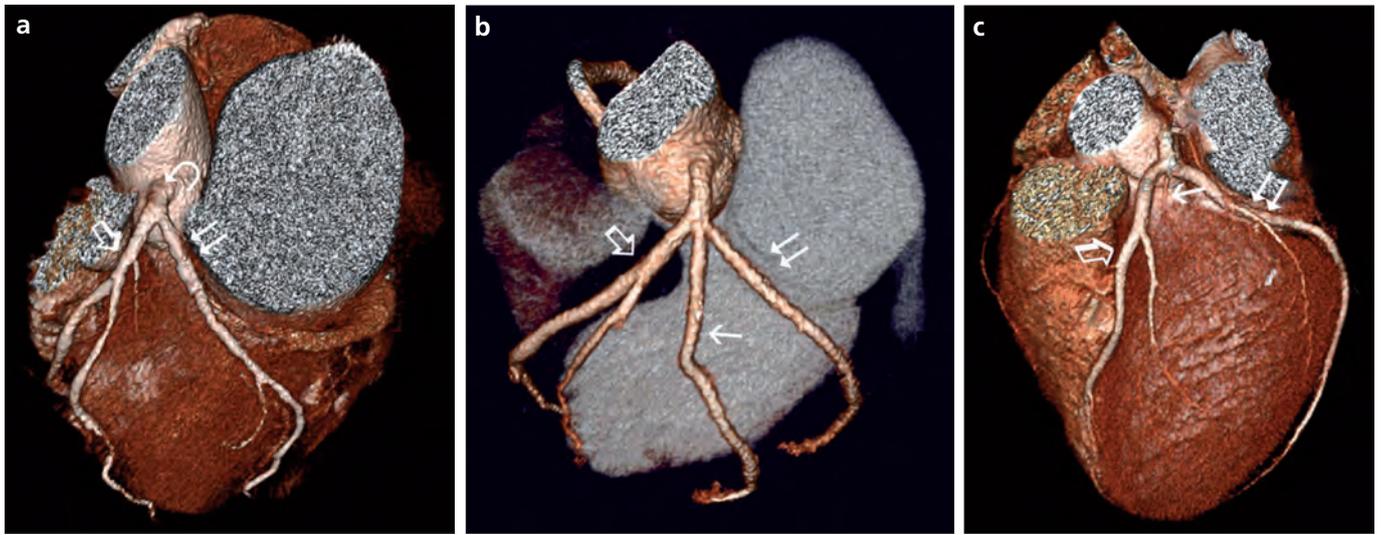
a–c. 3D volume-rendered CT angiography images of 3 different patients (a–c) show the left main coronary artery (*curved arrow*) that bifurcates to the left anterior descending artery (LAD) (*open arrow*) and circumflex artery (Cx) (*double arrow*) (a) and trifurcates where ramus intermedius (*straight arrow*) is seen in between the LAD (*open arrow*) and Cx (*double arrow*) (b). Ramus intermedius (*straight arrow*) may be variable in size, changing from a well-developed branching artery to a small one (c) (LAD, *open arrow*; Cx, *double arrow*).
